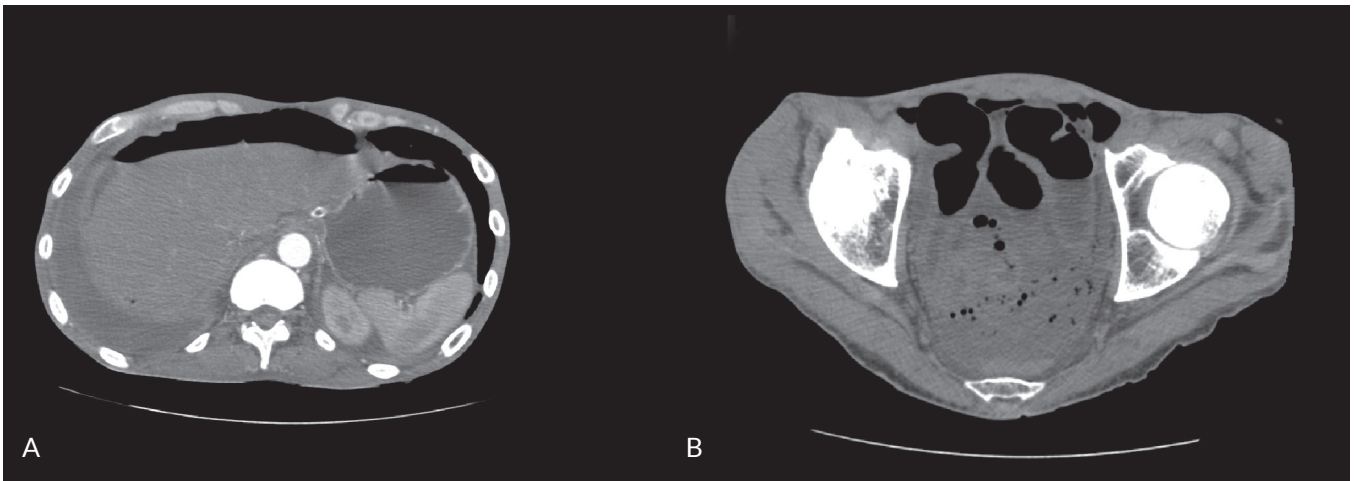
Non-contrast-enhanced CT on admission. A large volume of free gas in the abdominal cavity (A). In the pelvis, free purulent intraperitoneal fluid with gas bubbles (B)
